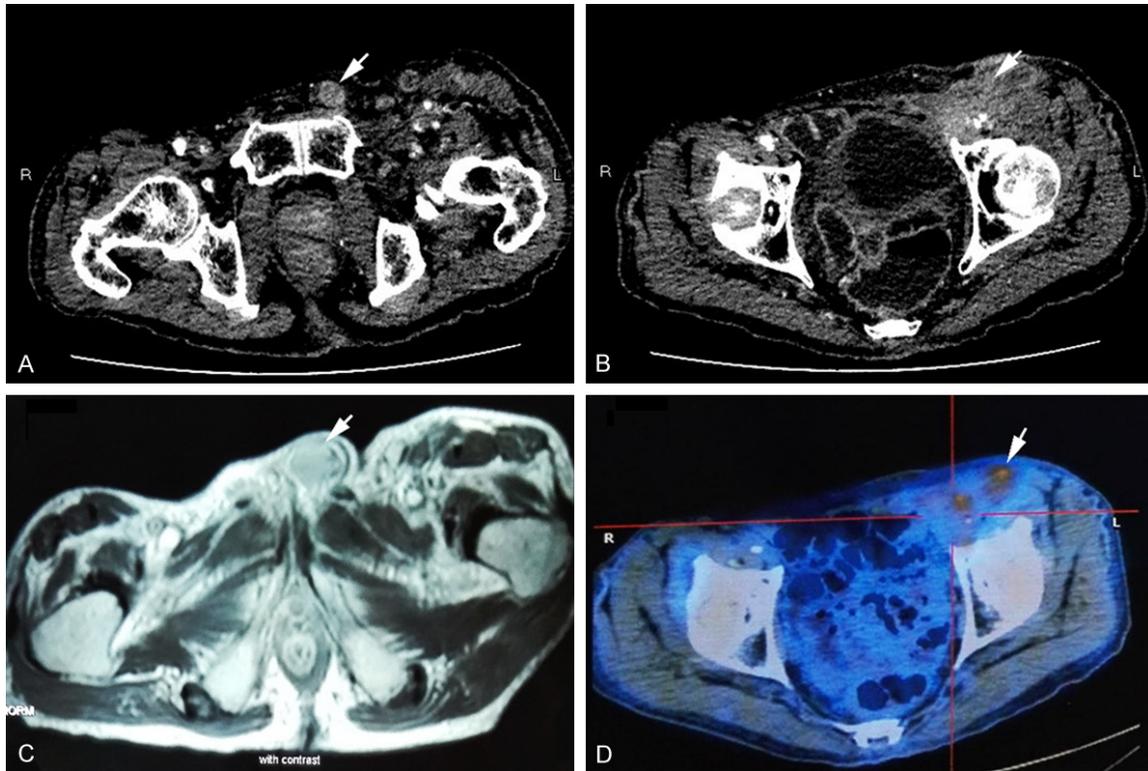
Radiographic findings of the patient after admission. Contrast-enhanced CT scan indicates: (A) The tumor in the left spermatic cord completely surrounds the left external iliac vein (white arrow); (B) Such spermatic cord tumor has heterogeneous density, with irregularly thickening of tumor margin near iliac fossa (white arrow). MRI image (C) shows a spermatic cord metastasis with no evidence of soft-tissue invasion (white arrow). Finally, PET-CT scan (D) confirms that GC metastatic to the sex cord due to significantly high glucose intake.
